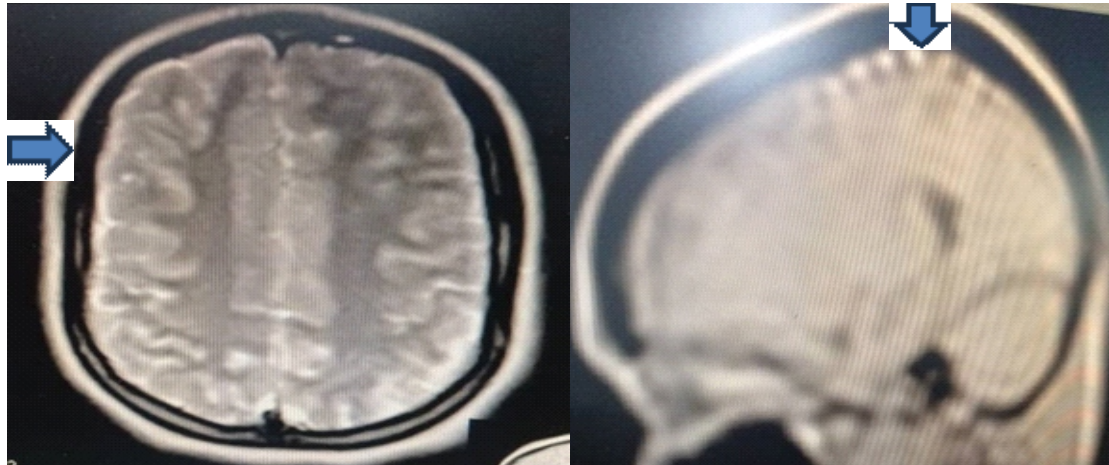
Cranial MRI (coronal and axial views) with cortical tubers
